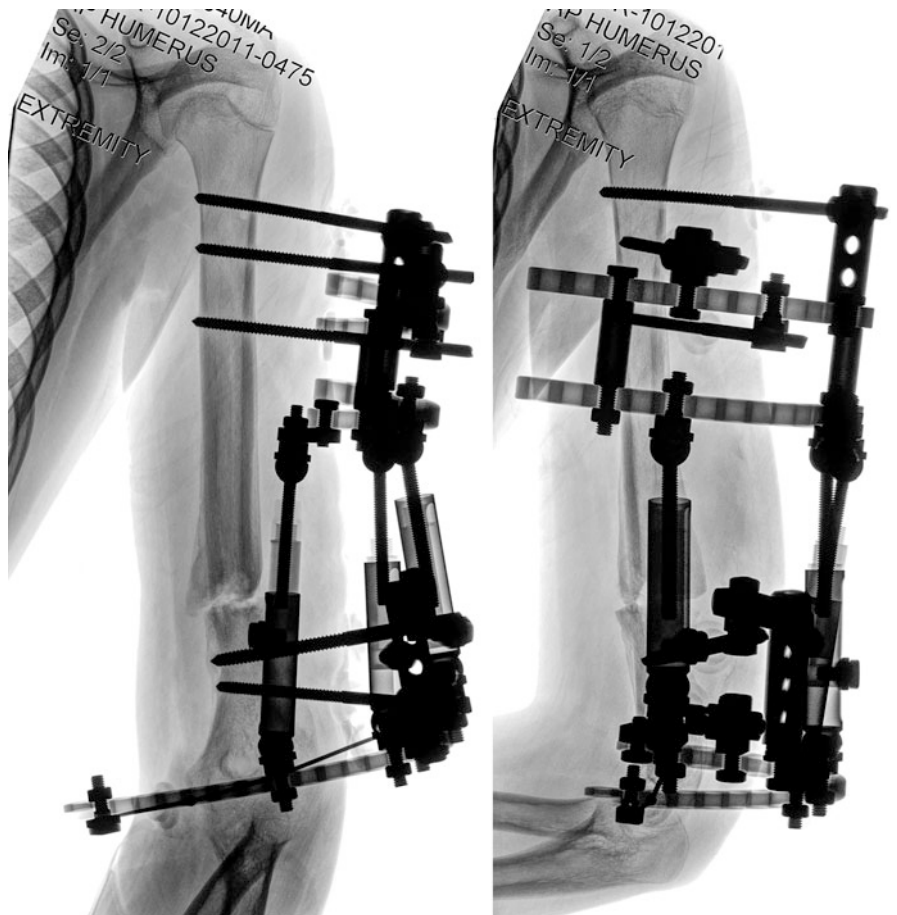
Radiographs of the humerus 4.5 months after surgery demonstrating solid mineralized callus. Fixator was removed 10 days later
